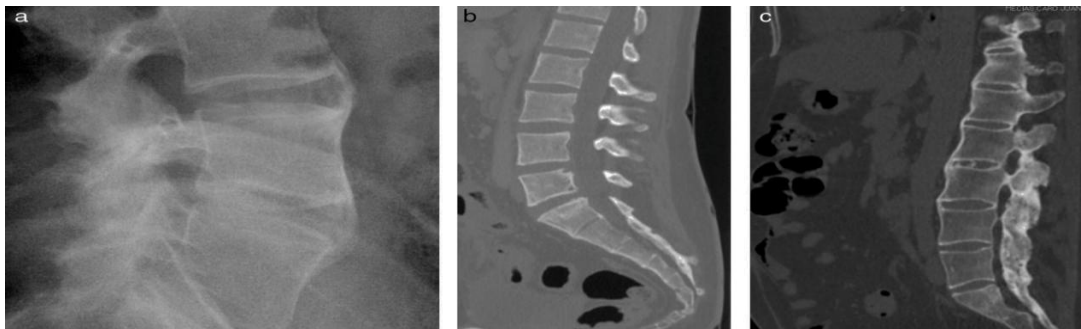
Lateral projection of the enlarged lumbar spine (a) and sagittal CT cuts in the bone window (b and c), where it is shown the sign of "shiny edges" or shiny corners
